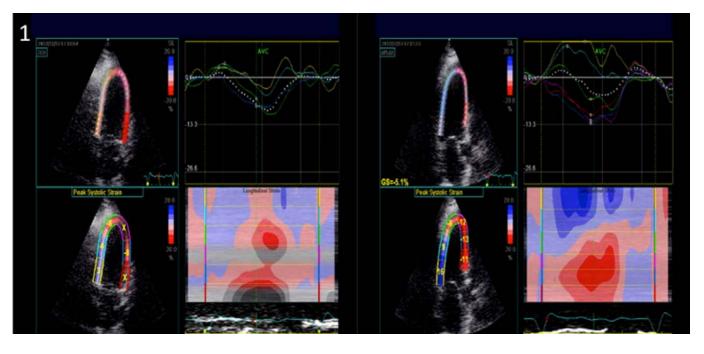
Paradoxical longitudinal strain in inferior and inferolateral walls in a patient admitted with uremic pericarditis and found to have newly reduced systolic function without any wall motion abnormalities, suggestive of perimyocarditis. The systolic function recovered following treatment for pericarditis in an echocardiogram performed 2 weeks later.
